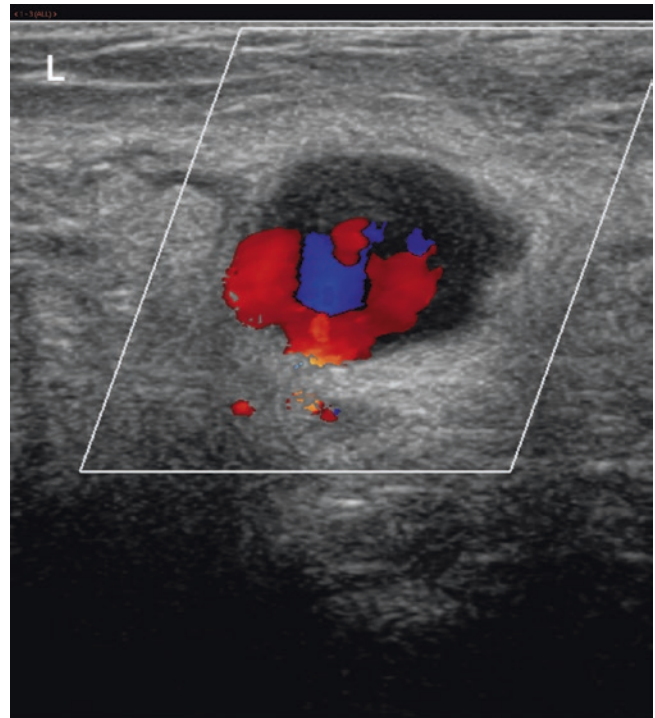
Turbulent flow on colour Doppler with 'yin-yang' appearance typical of pseudoaneurysm
